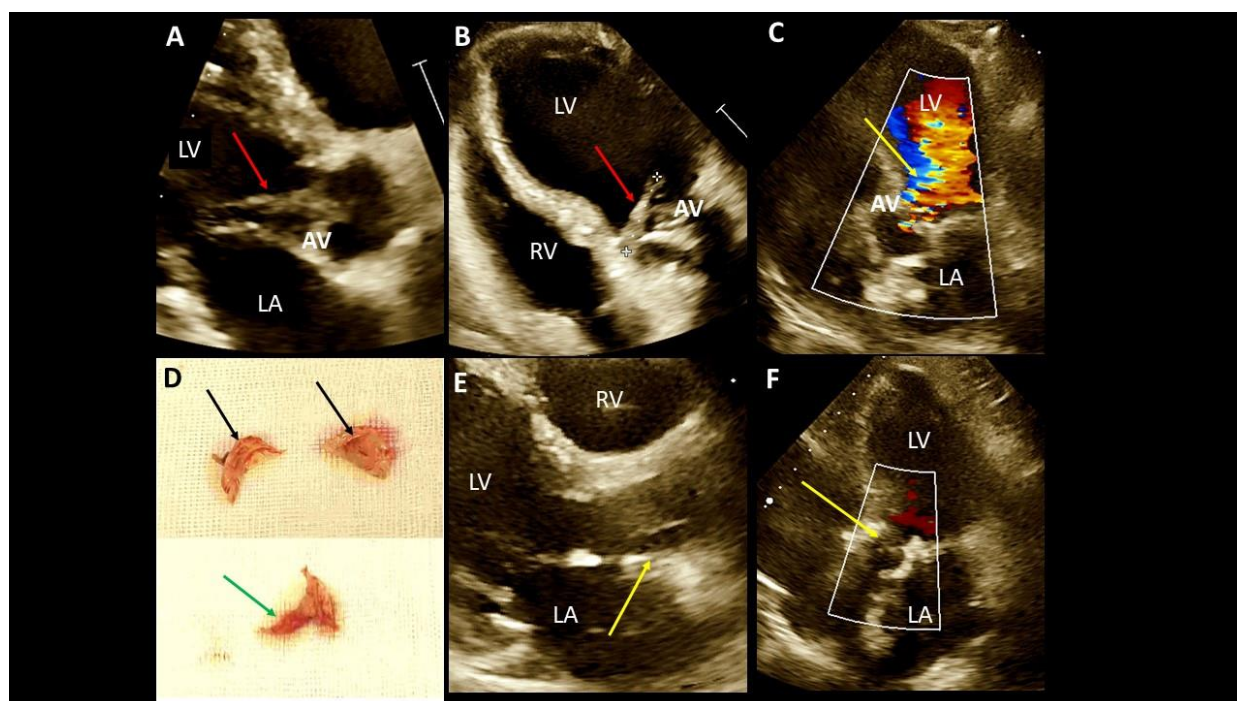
Transthoracic echocardiography in a patient with aortic valve endocarditis: A – long bacterial vegetation attached to the aortic valve (arrow); parasternal long axis view; B –
